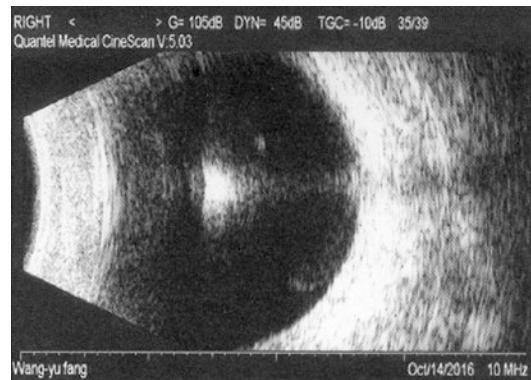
Ultrasonography of the injured eye demonstrating chaotic vitreous body and a high echo substance which was suspected to be the intraocular foreign body
